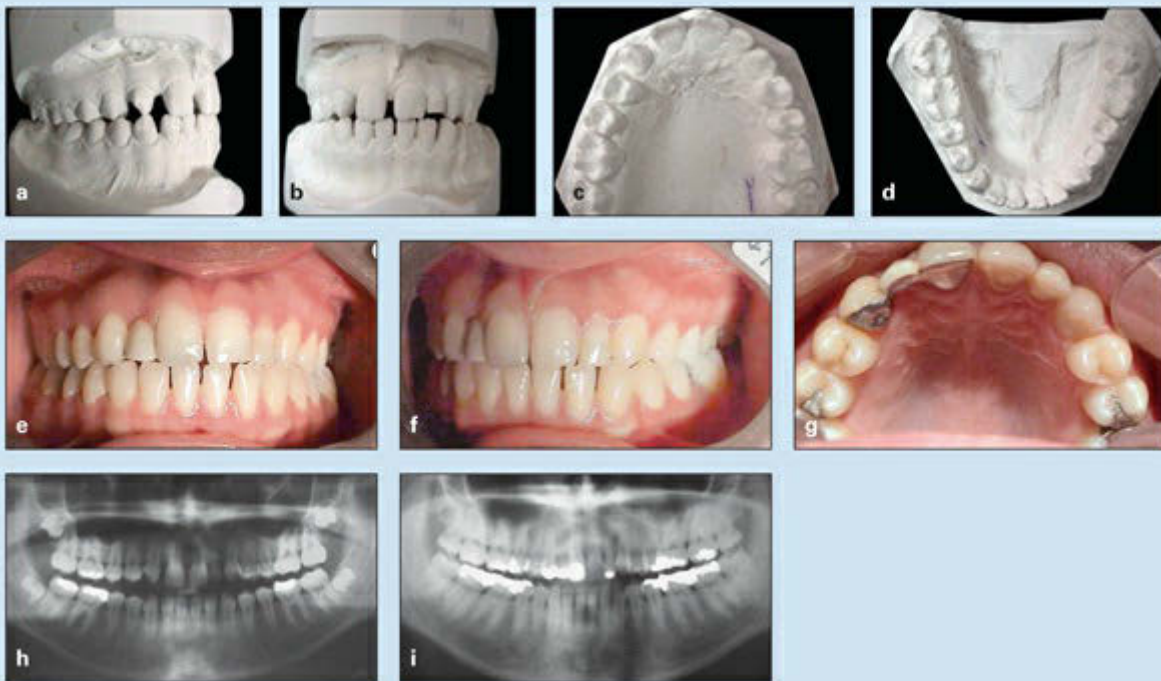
Treatment of a 13-year-old girl who is missing both maxillary lateral incisors. The left primary lateral incisor is present. (a to d) Pretreatment casts of the occlusion. (e to g) Posttreatment occlusion, after orthodontic treatment and placement of a resin-bonded prosthesis. (h) Posttreatment panoramic radiograph. (i) Postretention panoramic radiograph, revealing the good condition of the retained primary lateral incisor 8 years after treatment.
